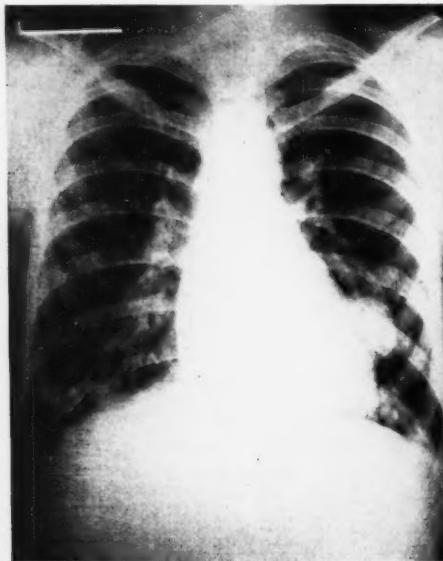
Roentgenogram, anteroposterior view, of the chest taken in November 1947. The nodular shadows in both lower lobes are readily seen.
